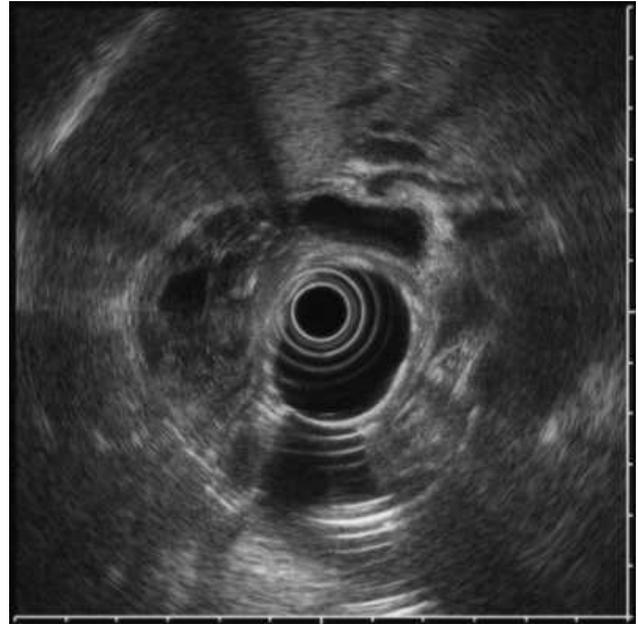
Endoscopic ultrasonography showed irregular thickening of the gallbladder wall with an acoustic shadow inside. The border between the gallbladder and liver was unclear in some areas.
